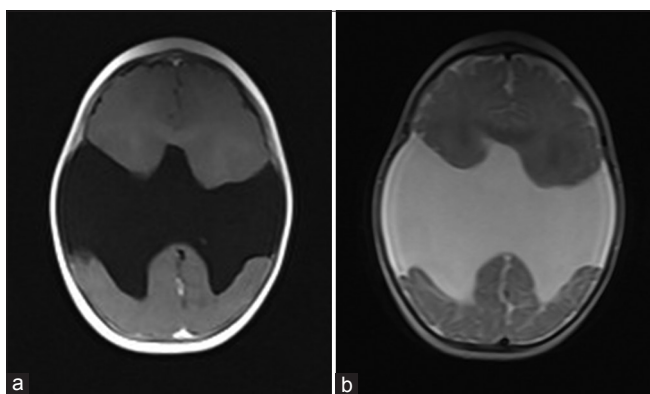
(a and b) Axial T1- and T2-weighted magnetic resonance imaging images of a 4-year-old demonstrates bilateral cleft communicating with the subarachnoid spaces and lined by heterotopic gray matter. The characteristic batwing appearance is noted
